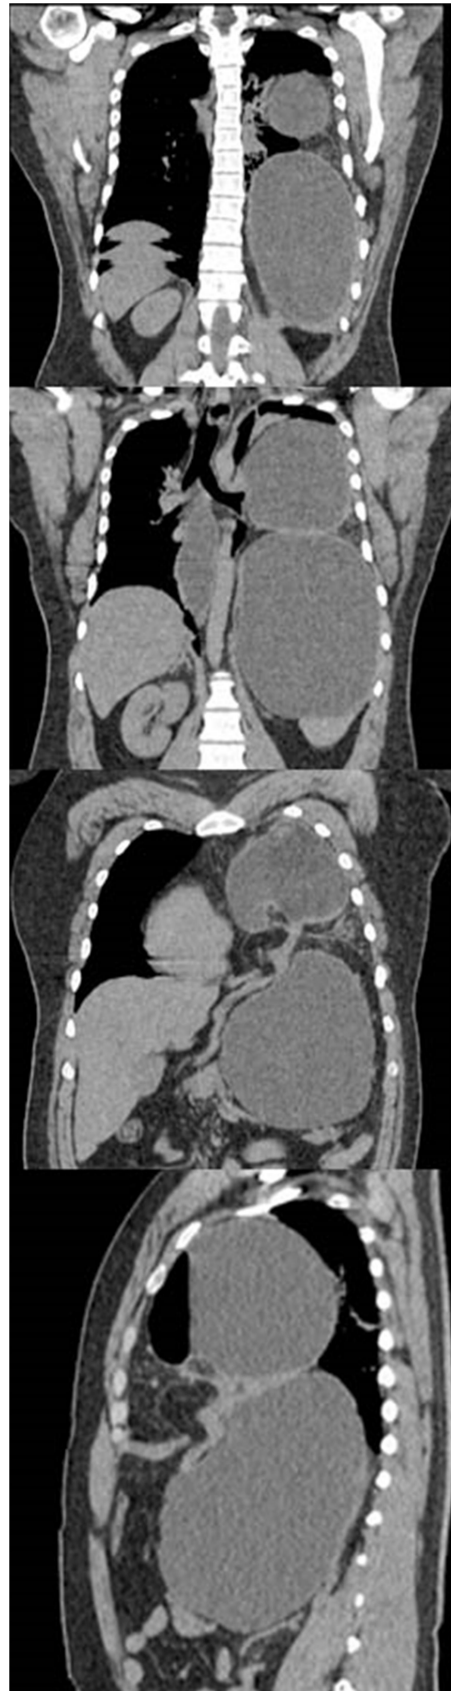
Computed tomography showing an intrathoracic stomach with mesenteroaxial rotation and left pulmonary compression.
